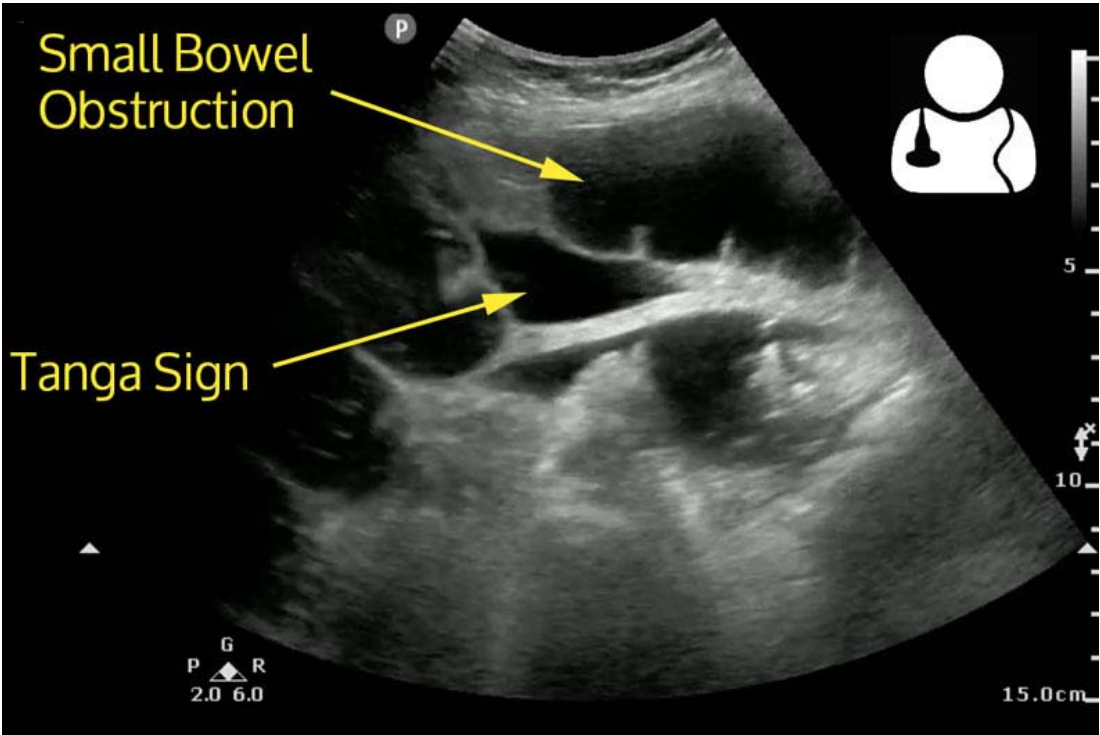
Ultrasound image showing a dilated loop of bowel and extra-luminal free fluid known as "Tanga sign " [56]
